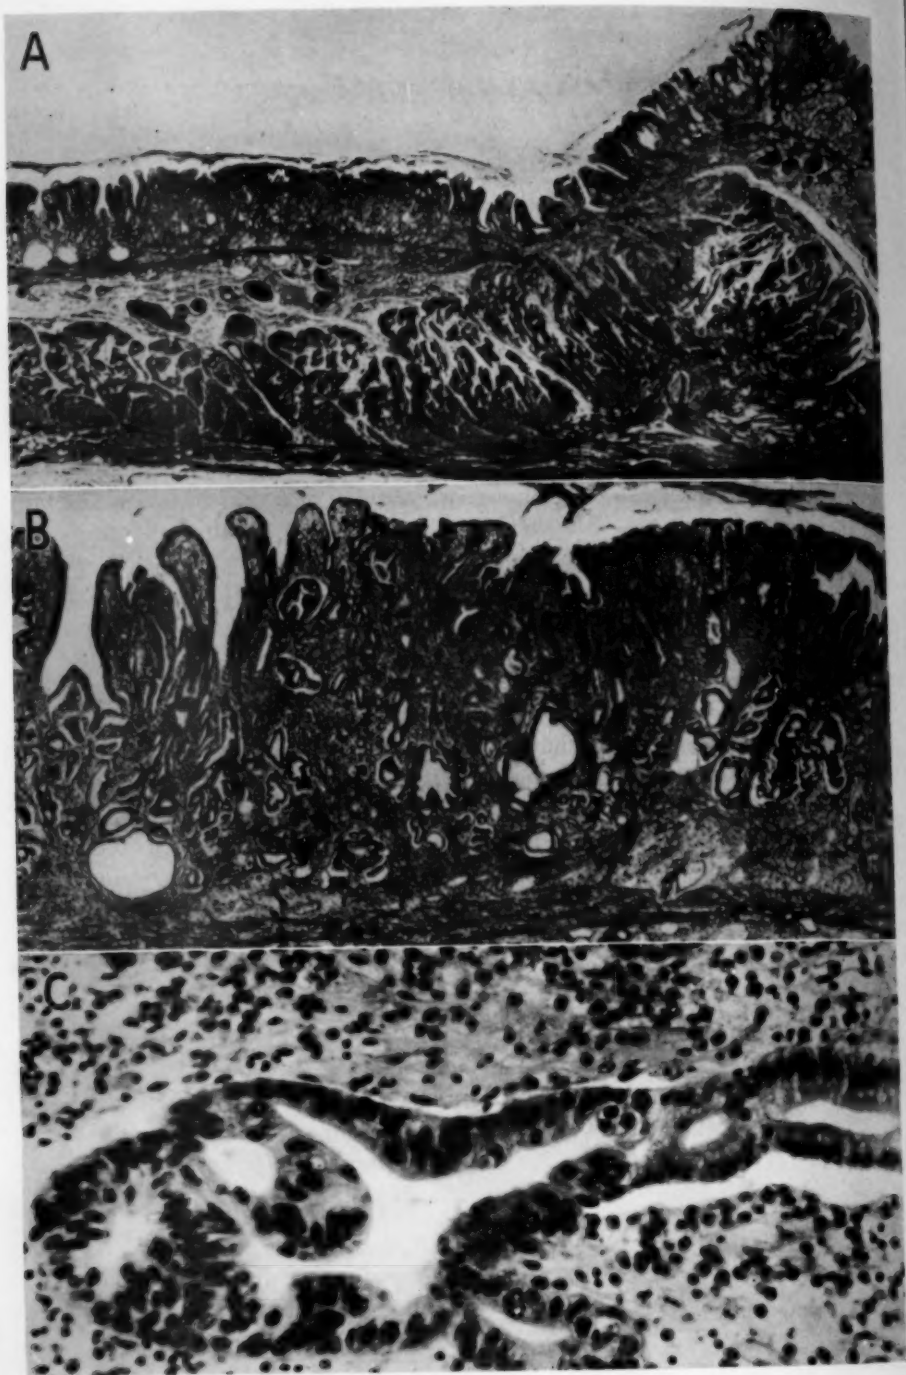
A*, carcinoma in situ of the prepyloric region, filling the site of an ulcer visualized in a roentgenogram three months before (case 1); $\times 10$.
